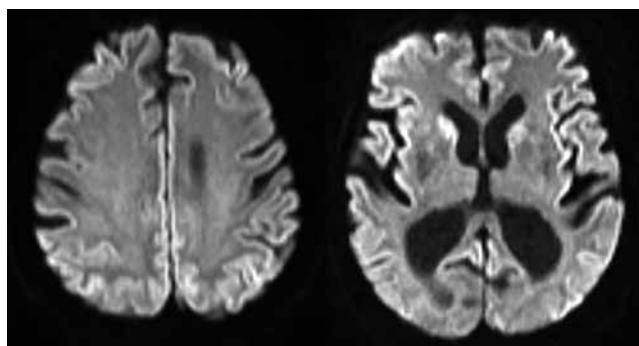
MRI axial cuts showing hyperintensity in areas of the cortex (cortical ribboning) and in caudate nucleus at the DWI sequence.
